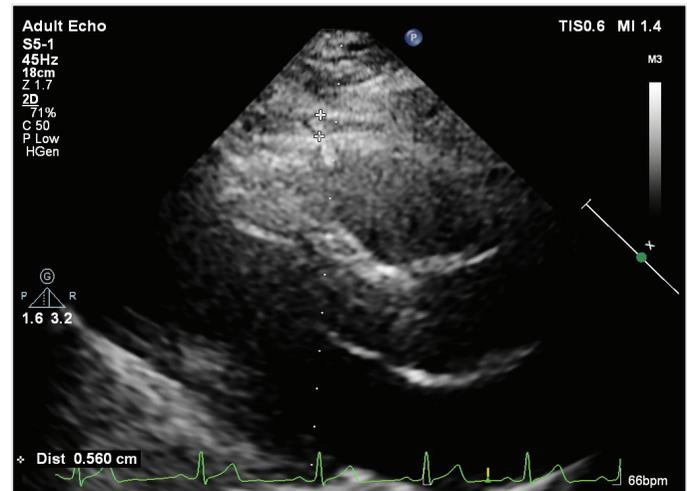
Evaluation of epicardial adipose tissue thickness by echocardiography
